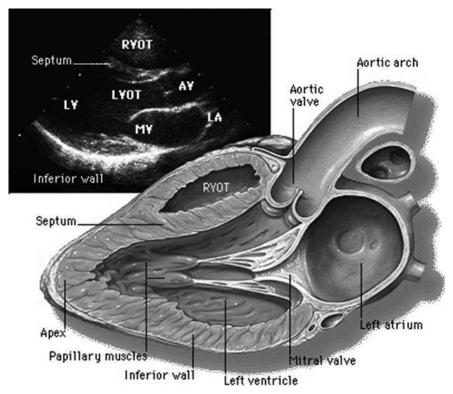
Transesophageal echo (TEE) image depicting normal anatomy of the heart
